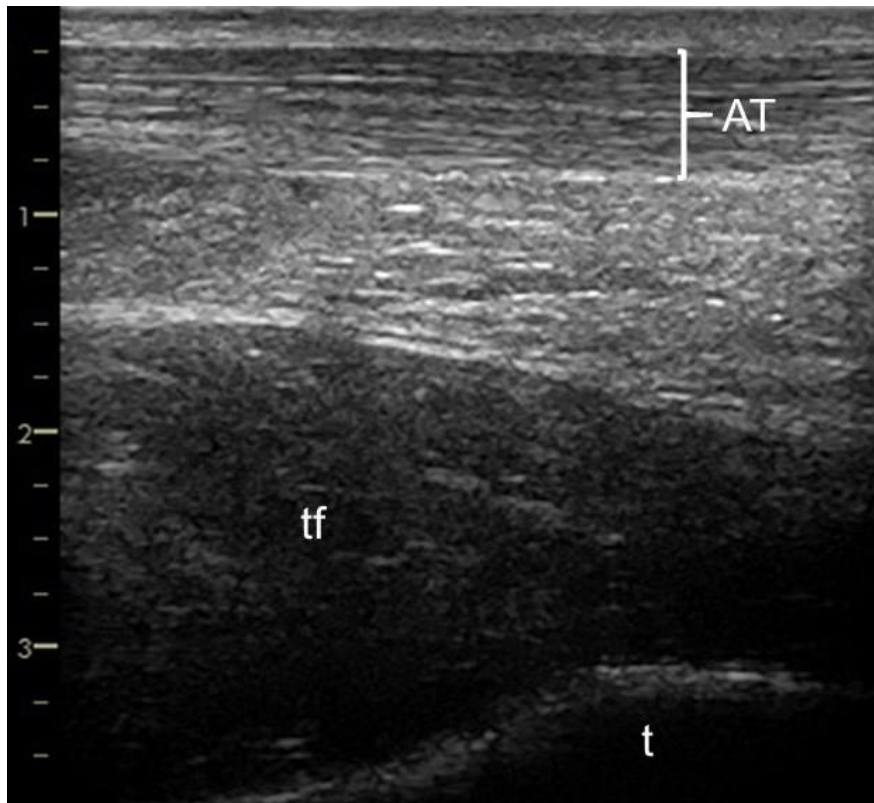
A long axis ultrasound image of a human Achilles tendon with the typical striated speckle pattern. The axis on the left indicates depth in cm. AT = Achilles tendon, tf = toe flexors, t = tibia.
